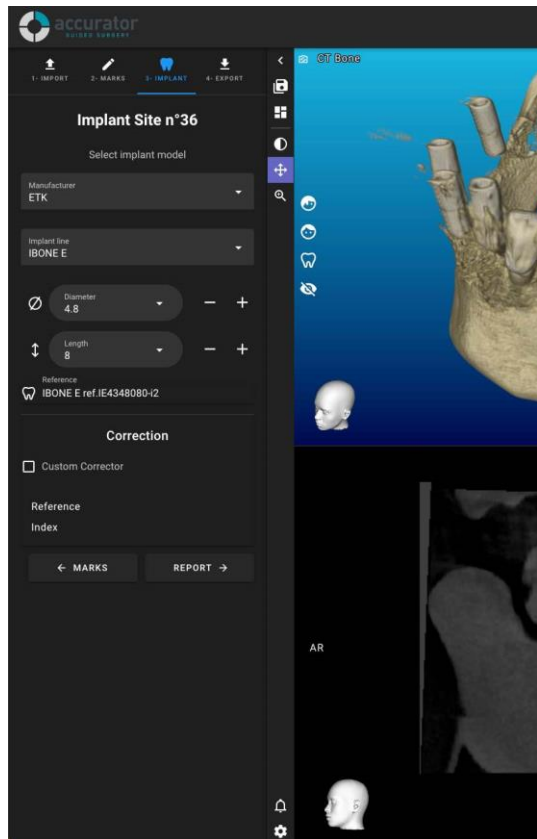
Figure 4: CBCT navigation planning interface showing multiplanar views (axial, sagittal, coronal) with superimposed 3D surface scan of teeth. Virtual implant crowns are positioned in proper occlusal relationship, with underlying virtual implant axes demonstrating prosthetically-driven planning that ensures ideal emergence profiles and biomechanical positioning.
